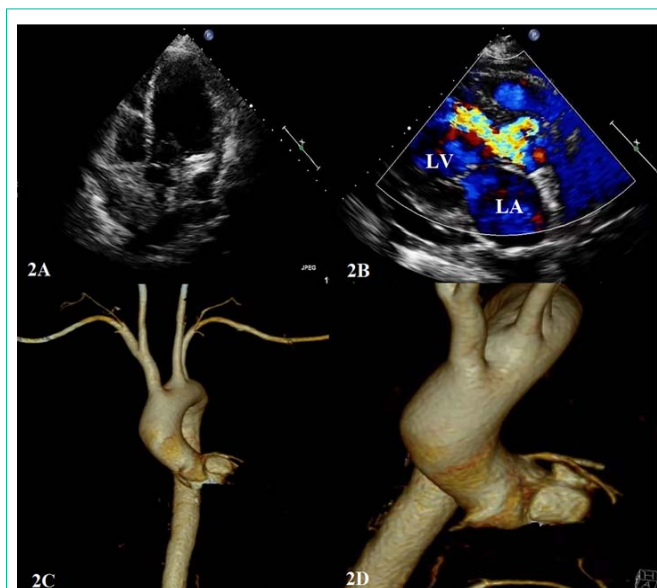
A: SVA from left coronary sinus rupturing into LV (arrow); B: blood flow signal from left coronary sinus to LV; C and D: CTA images of patients.
